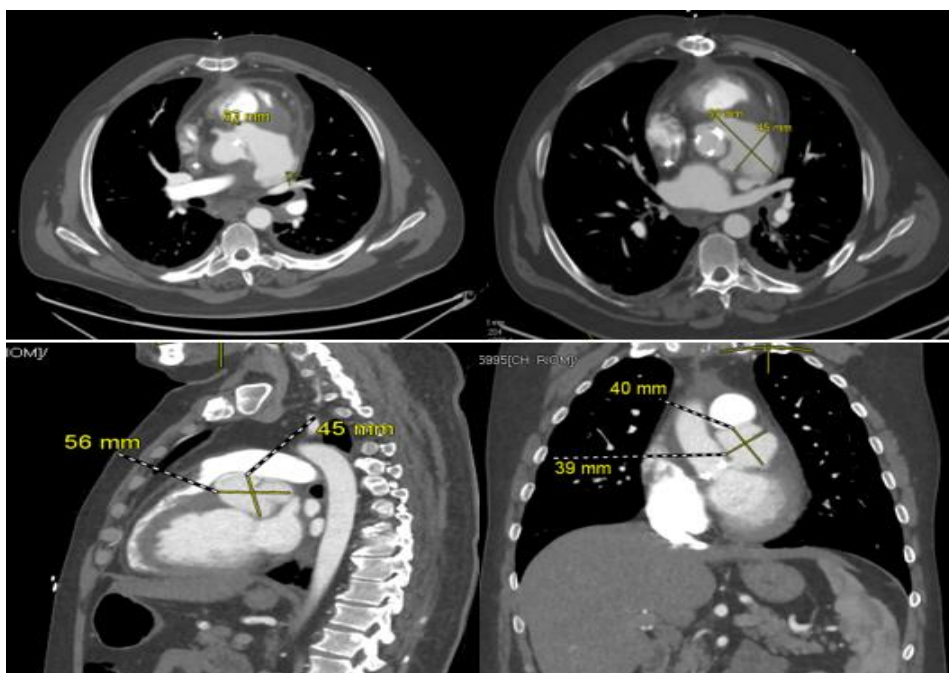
Thoracic CT scan: a LVOT pseudoaneurysm
